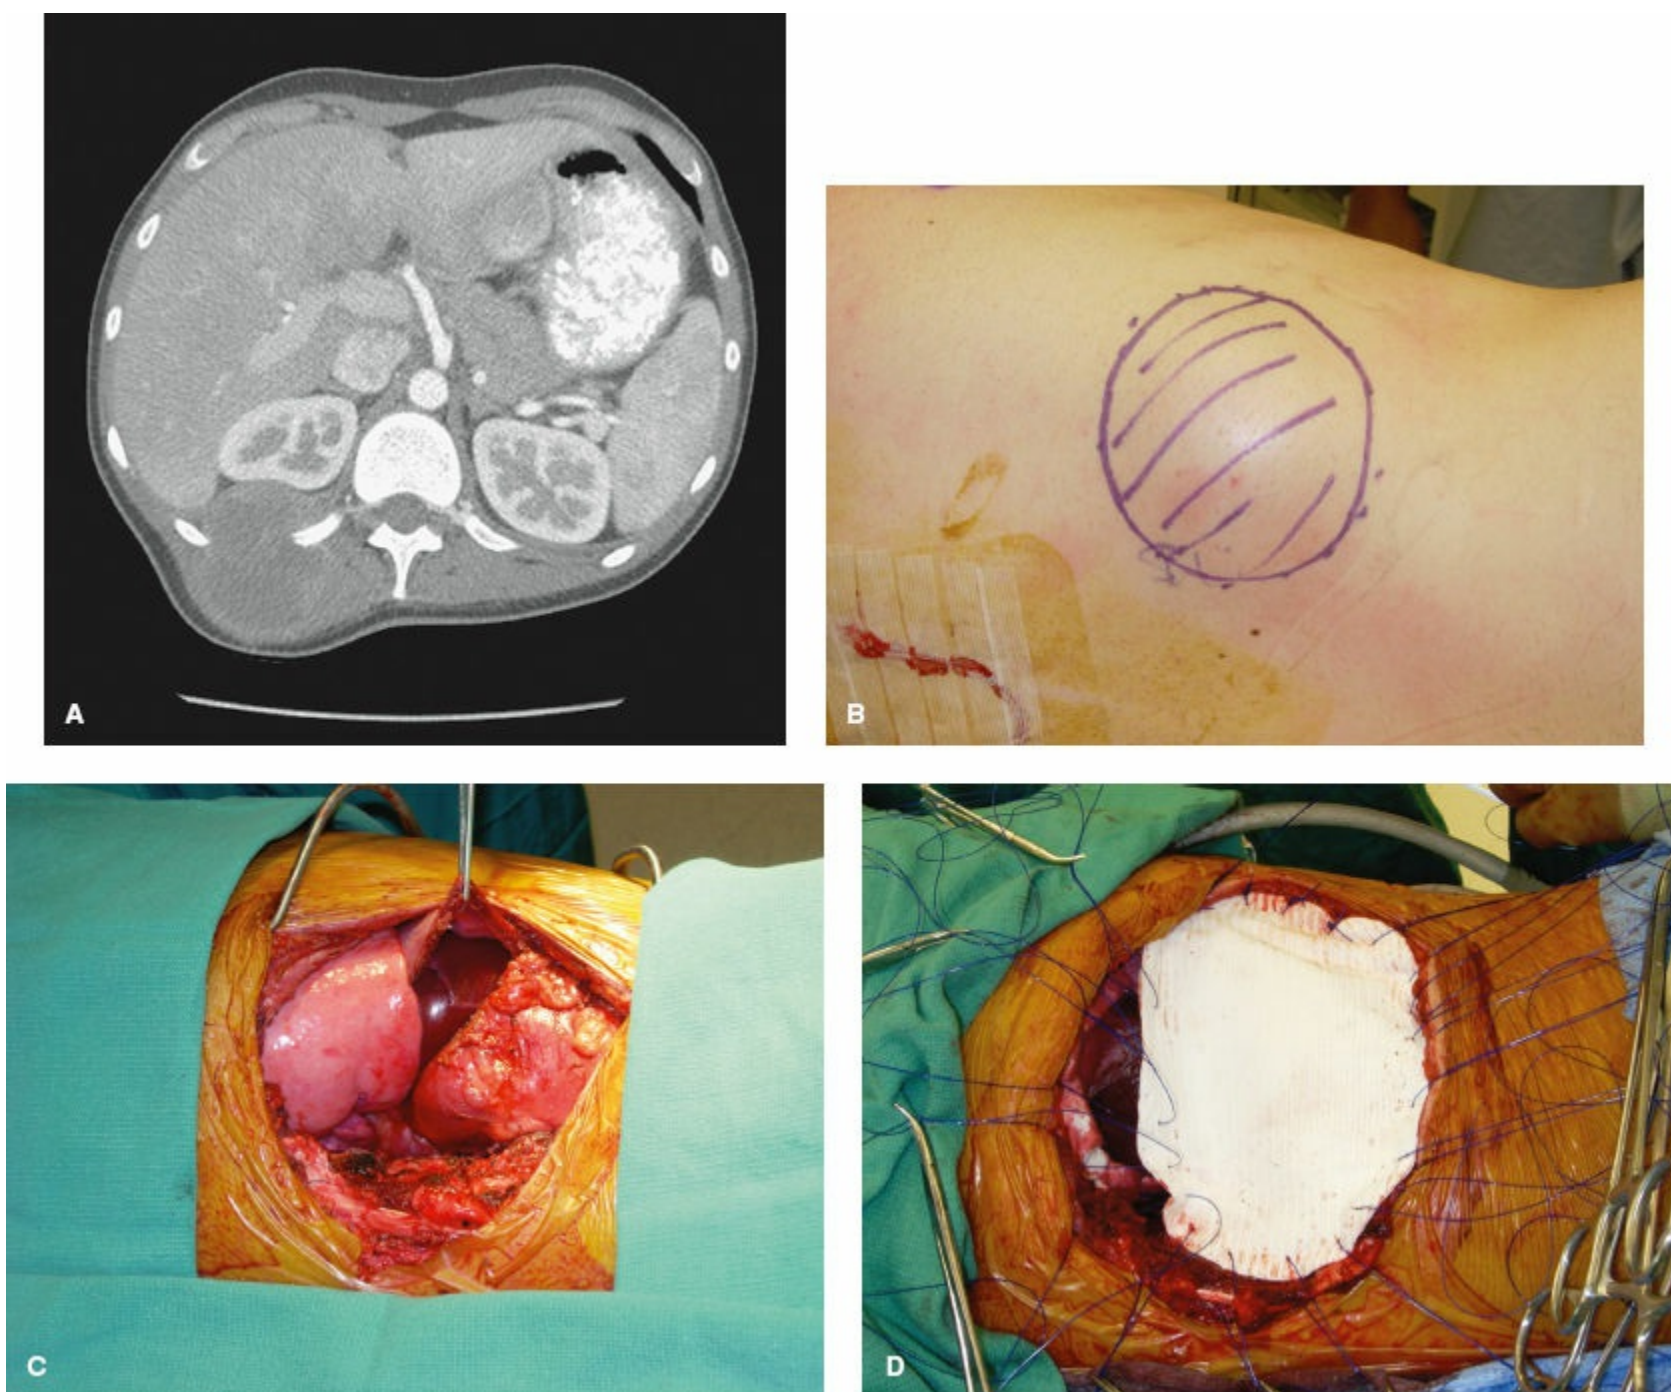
Chest wall sarcoma. A 20-year old man with a 7.5-cm right posterior chest wall epithelioid sarcoma involves the 11th and 12th ribs as seen on CT scan (A) and on physical examination (B). Chest wall resection was performed, including a portion of diaphragm. Resulting chest wall defect (C) was repaired using prosthetic mesh (D).
